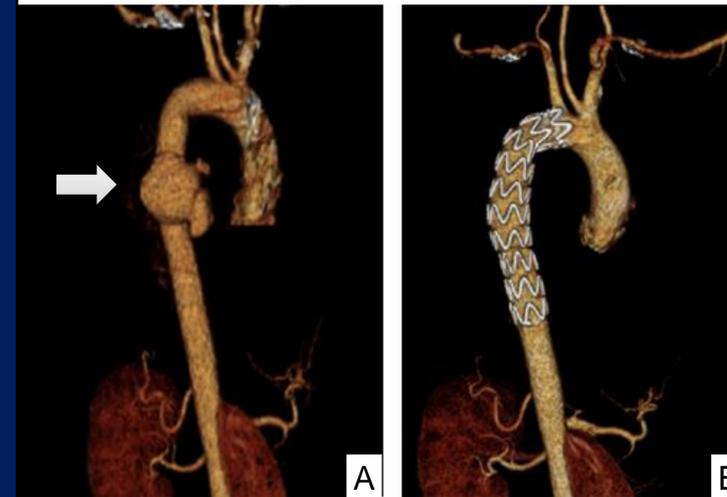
3D reconstruction of the aorta from CTA; images from before and after TEVAR. These are posterolateral views of the ascending aorta, aortic arch, and the descending aorta. Panel A shows the MAA (arrow) prior to TEVAR. Panel B shows the descending thoracic aorta repaired after TEVAR.
